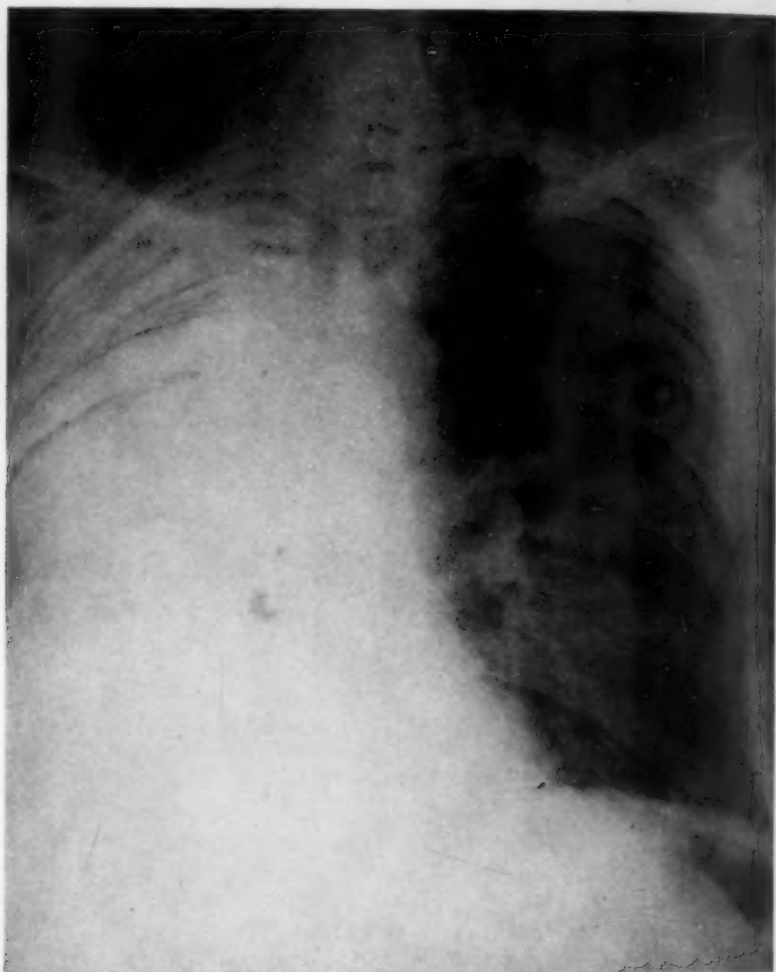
Chest x-ray February 19, 1947. Homogeneous opacity of right hemithorax. Retraction of trachea and mediastinal structures to right side. Bullous emphysema of upper left lung field. Mottled infiltration in lower left lung field. Increased density at left base.
